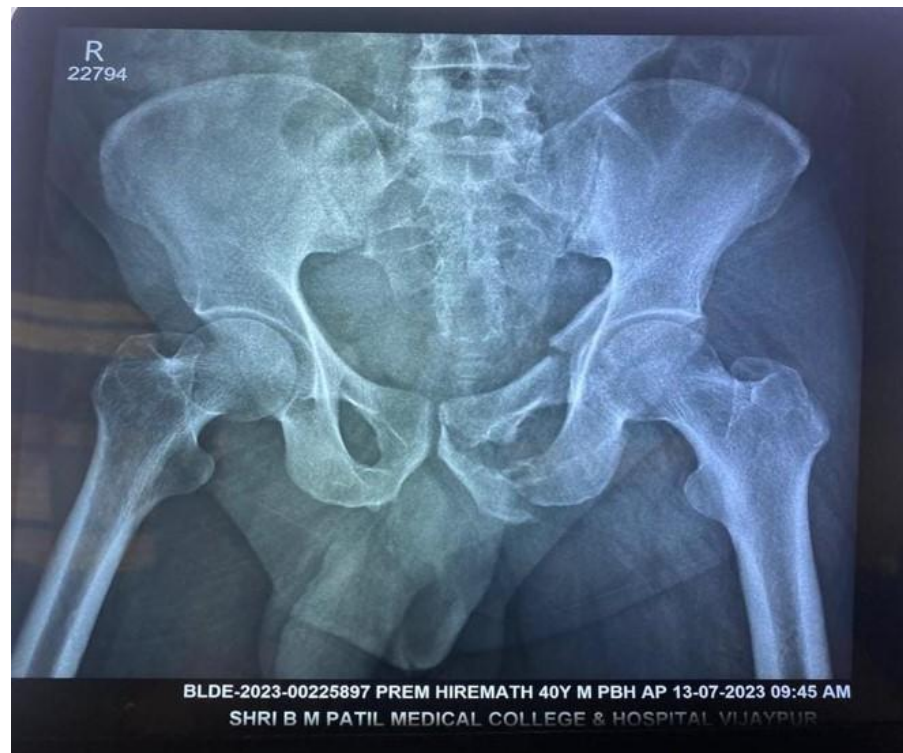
X-ray PBHS showing anterior column acetabular fracture of left side
